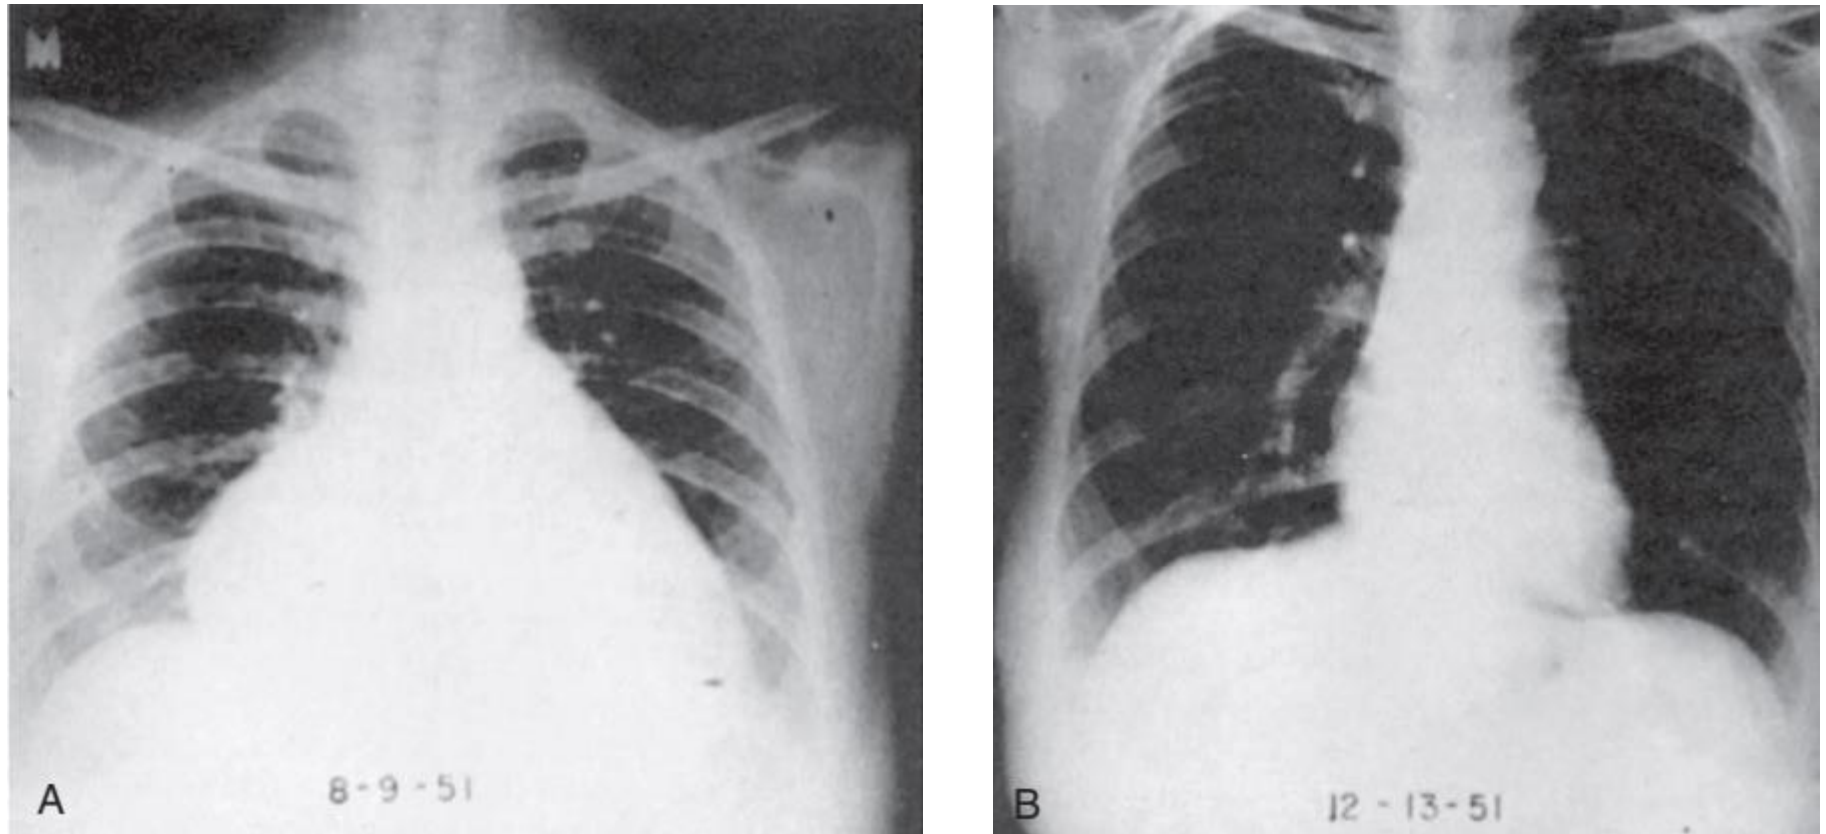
(A and B) Chest roentgenograms in a patient with myxedema heart disease. The patient had signs of severe congestive heart failure and was given thyroid hormone alone. Within 4 months, the heart had returned to normal size (B) and there was no evidence of underlying heart disease.
